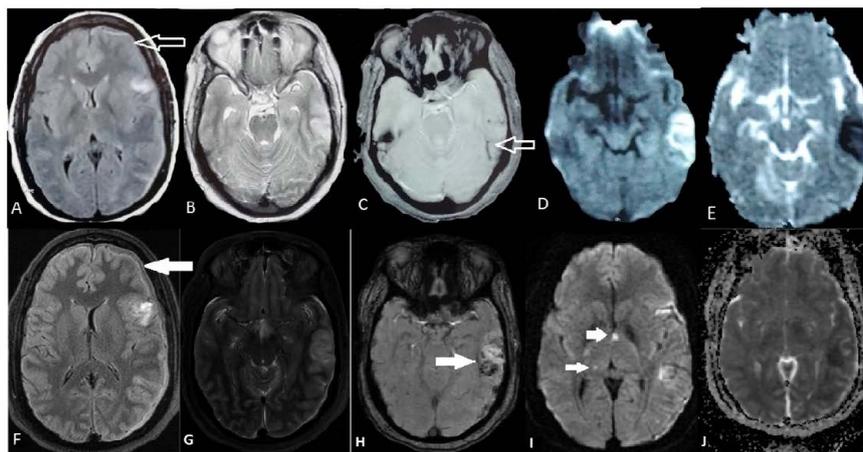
(A-E): shows multiple sequences [FLAIR, T2, SWI and DWI] of MRI of Brain showing SDH along left fronto-temporo-parietal region [indicated by arrow in A] with SAH along sulci of left cerebral hemisphere [indicated by arrow in C] and infarcts with hemorrhagic transformation in the left temporal and frontoparietal region [C and D]. Figure 1 (F-J): shows the follow up MRI showing similar sequences with increase in the size and extent of SDH [indicated by solid arrow in F] and increase in infarcts with appearance of new lesions in bilateral thalamus [indicated by solid arrow in I] and increase in the size of hemorrhagic transformation [indicated by solid arrow in H].
